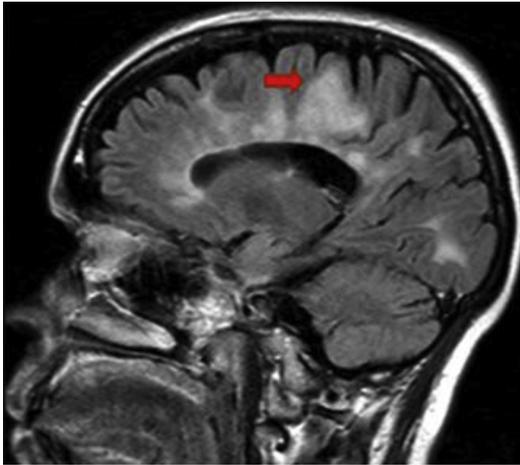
Sagittal FLAIR image demonstrates a large juxtacortical lesion (arrow).
